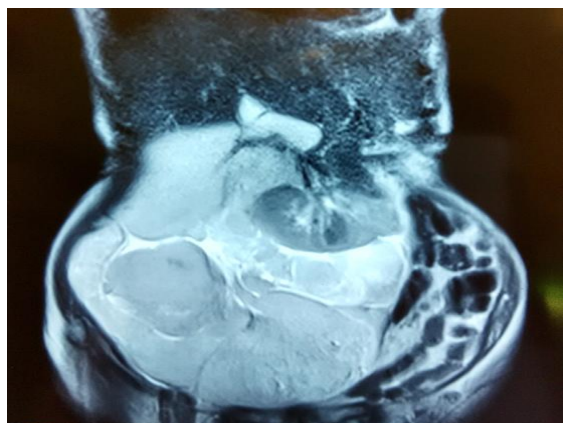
CT scan axial and coronal views showing retroperitoneal liposarcoma with anterior displacement of kidney
